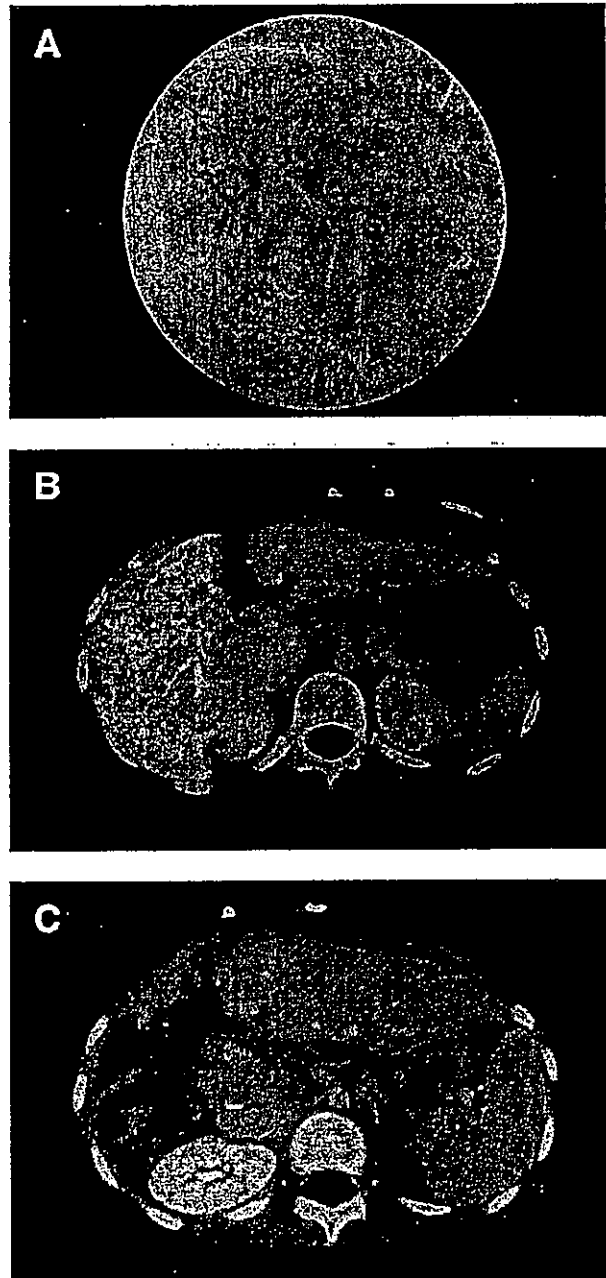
(A) Portal phase of angiology shows cavernous transformation of the native right portal vein after portal vein diversion. (B) After PTPE for native right portal vein. Right portal vein was occluded by Lipiodol. (C) CT after native right hepatectomy. The volumetric analysis showed 416 mL in the graft and 106 mL in the native caudate lobe.
